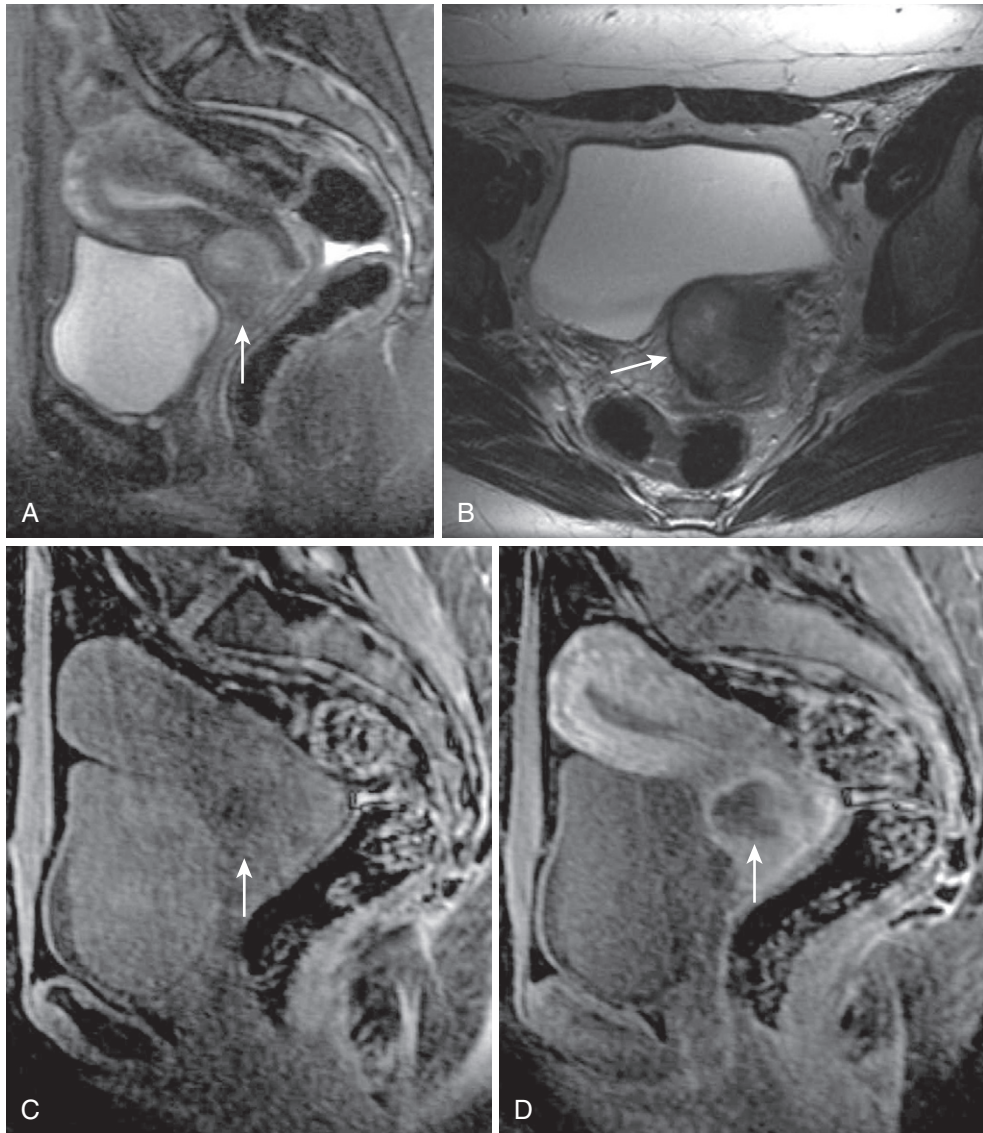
Cervical carcinoma. An ill-defined mildly hyperintense lesion (*arrow*; hypointense to endometrium and hyperintense compared with fibrous stroma) invades anteriorly on sagittal (A) and axial (B) T2-weighted images. Comparing precontrast (C) with post-contrast (D) images confirms enhancement and relative hypovascularity.
